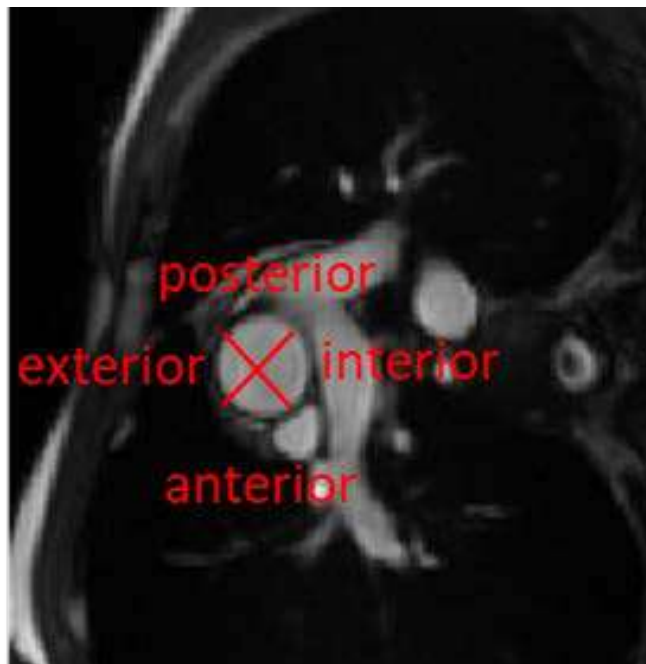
MRI image where ascending aorta is divided in four quadrants.
